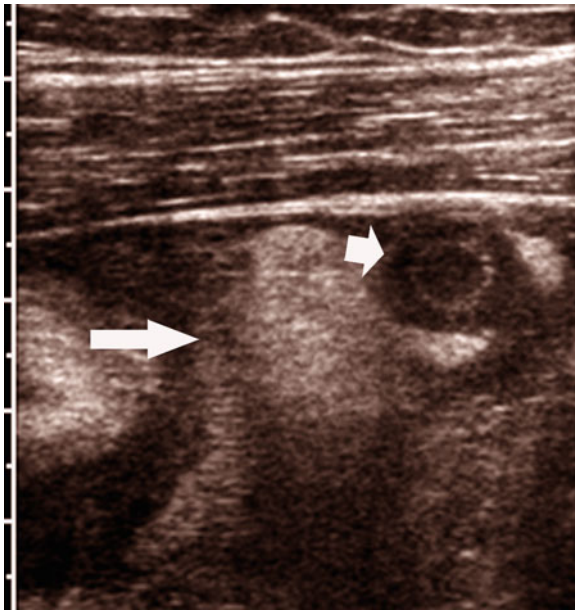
Inflamed periappendiceal fat as secondary sign of appendicitis. Grayscale sonogram through short axis of appendix (*short arrow*) demonstrates mural thickening of wall of appendix. Note prominent echogenic fat adjacent to inflamed appendix (*long arrow*)
